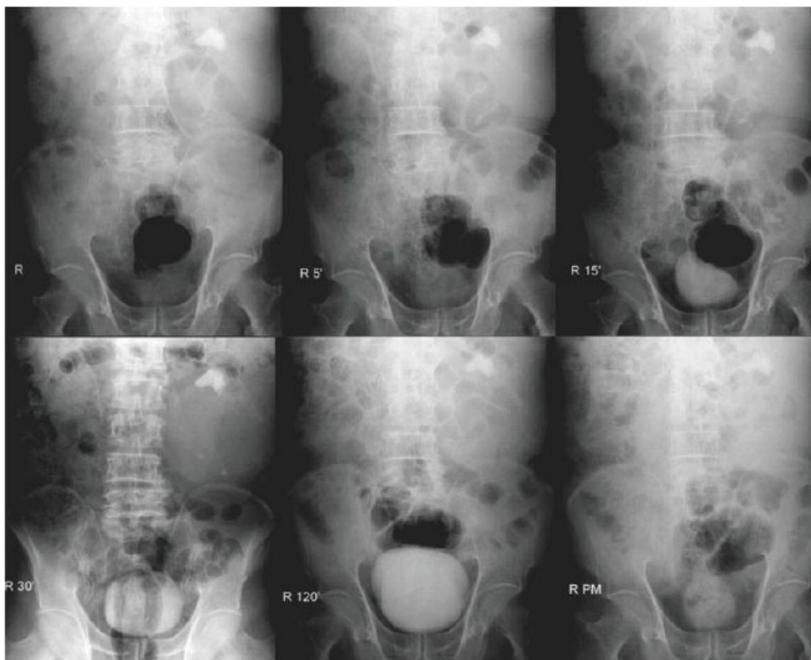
The Kidney-ureter-bladder (KUB) radiography and intravenous urography (IVU) could not reveal the abnormality other than a left kidney stone.
